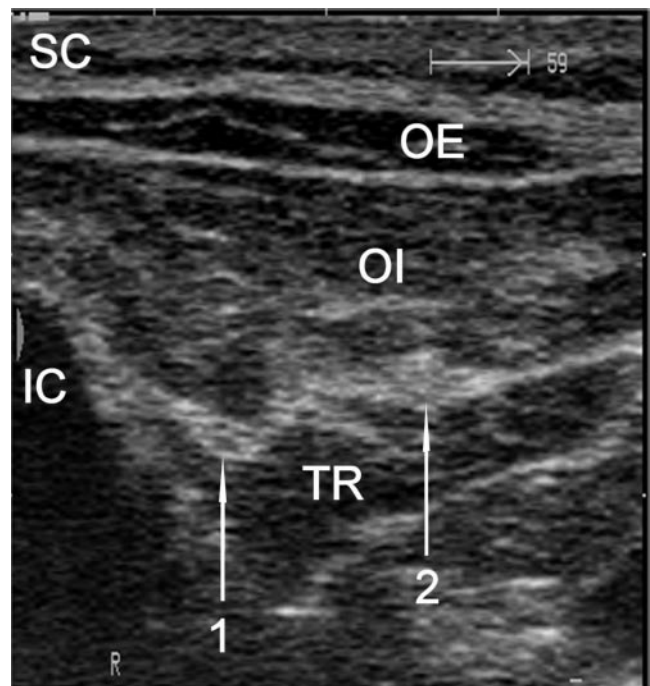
Ultrasound image obtained by the transducer position showed in Figure 1. 1, II nerve; 2, IH nerve; IC, iliac crest; SC, subcutaneous tissue; OE, external oblique muscle; OI, internal oblique muscle; TR, transversal abdominal muscle.
